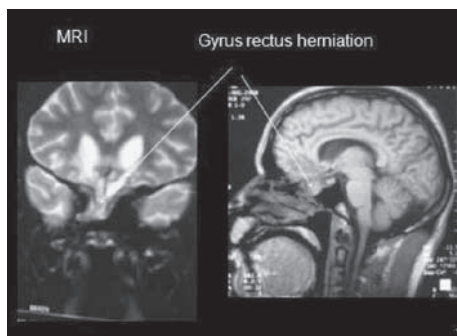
MRI Brain Coronal T1 W& Sagittal T2 W images showing the herniation of the gyrus rectus in to the sphenoid sinus with drag on the chiasma
